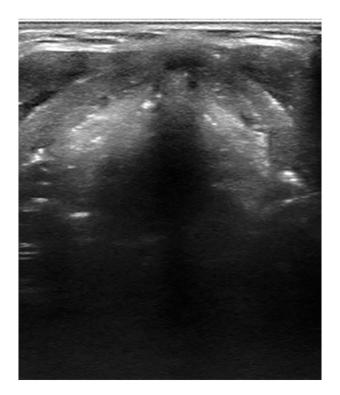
Sonographic appearance of the thyroid cartilage.
